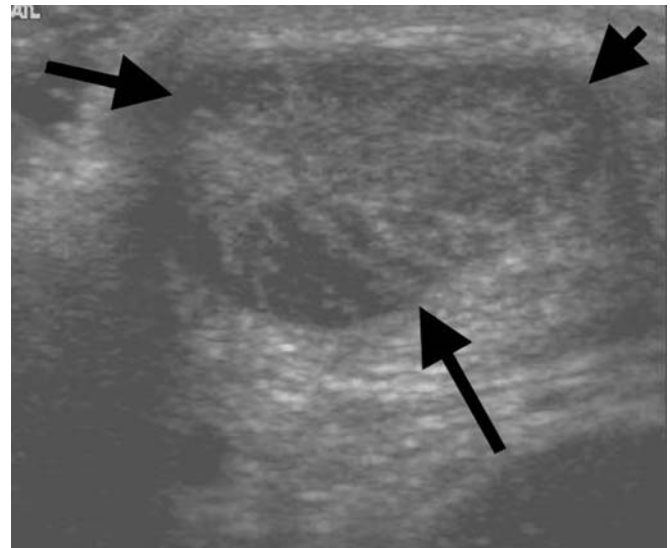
Transverse ultrasound of the Achilles tendon showing the marked thickening of tendinopathy (inside arrows).
